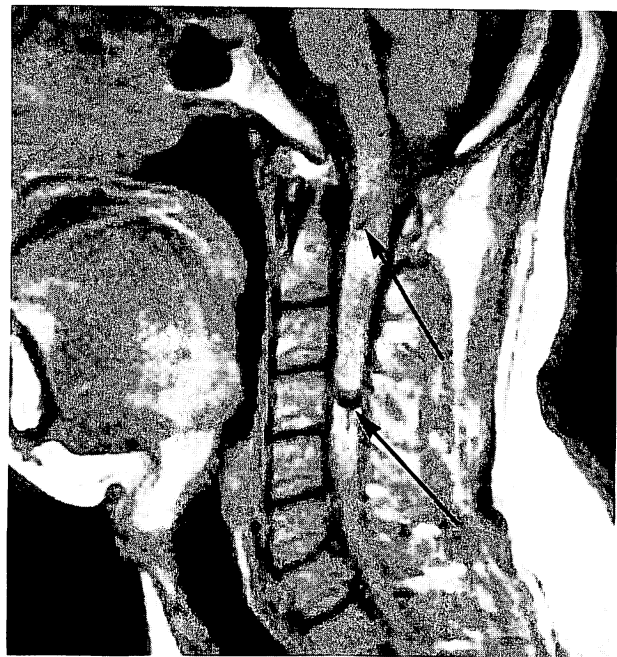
A 44-year-old male with a cervical intramedullary ependymoma. T1-weighted SE image. Surgery revealed an old hematoma at the upper and lower poles of the tumor. Arrows indicate old hematomas in the intramedullary tumor; they must be differentiated from calcification and syrinx
